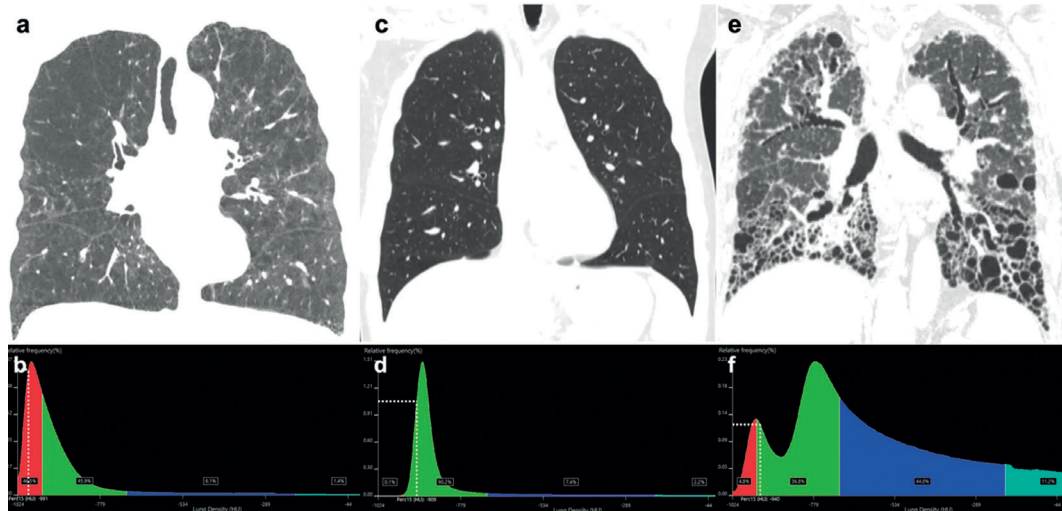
a, b A coronal CT scan with a lung window and lung density histogram for a COPD patient shows a median lung attenuation of -956 HU and an emphysema index (ranging from -1024 to -950 HU, indicated in red) of 46.5%. c, d In a coronal CT scan and lung density histogram of a healthy individual, the median lung attenuation is noted at -882 HU with a normal lung index of 90.2% (spanning -950 HU to -700 HU, depicted in green). This demonstrates a notable peak (kurtosis) and an asymmetrical curve, typically skewed to the right. e, f The coronal CT and lung density histogram evaluation of a severe idiopathic pulmonary fibrosis (IPF) patient reveals a markedly low median lung attenuation of -611 HU, diminished kurtosis (less pronounced peak), a skew towards more symmetric distribution around higher values, and a high-attenuation area percentage (ranging from -700 to +50 HU, shown in blue and light green) of 55,2%.
